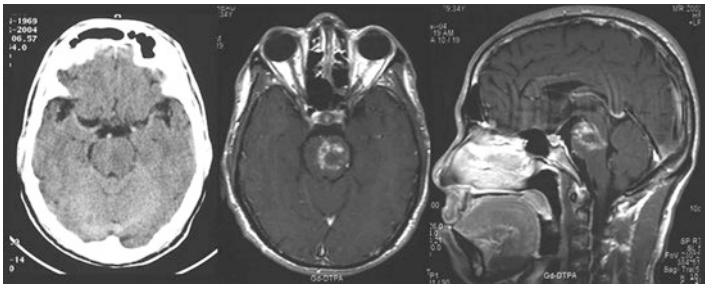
The CT scan on the left hardly gives any clue of the fatal brain stem glioma easily displayed by the MRI. *If the patient has obvious clinical signs and symptoms, then you must scrutinize the image for the hidden clue which here is the enlarged pons and central low density. Remember to have a contrast enhanced image!*
